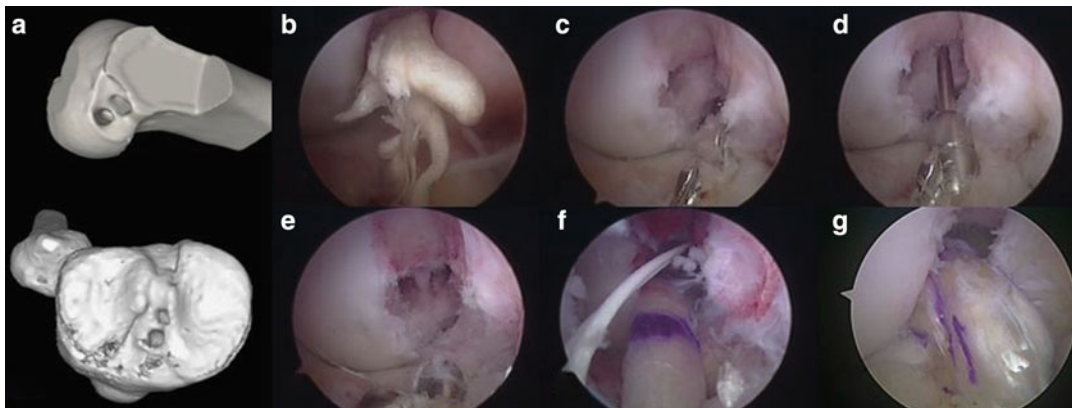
ACL single bundle revision surgery after a non-anatomic primary double bundle ACL reconstruction. (a) 3D-CT scan showing PL tunnel within the ACL insertion site and a high AM tunnel in the femur. Tibial
